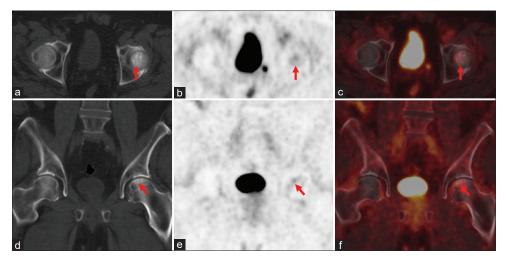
(a) Axial computed tomography. (b) Axial ¹⁸F-DCFPyL-positron-emission tomography. (c) Axial ¹⁸F-DCFPyL-positron-emission tomography/computed tomography images through the pelvis shows a focus of uptake in the left femoral head fusing to sclerotic bone changes (red arrows). Excreted radiotracer in the left ureter and bladder is present; the patient's biopsy-proven locally recurrent disease is not visible on these images but was intensely radiotracer-avid. (d) Coronal computed tomography. (e) coronal ¹⁸F-DCFPyL positron-emission tomography. (f) Coronal ¹⁸F-DCFPyL positron-emission tomography. (e) coronal ¹⁸F-DCFPyL positron-emission tomography. (f) Coronal ¹⁸F-DCFPyL positron-emission tomography recapitulates the findings on the axial images, with more clear delineation that the sclerotic changes are along the articular surface of the left femoral head. These findings confirmed that the newly appearing uptake on the bone scan shown in Figure 1b was most consistent with left femoral head avascular necrosis
